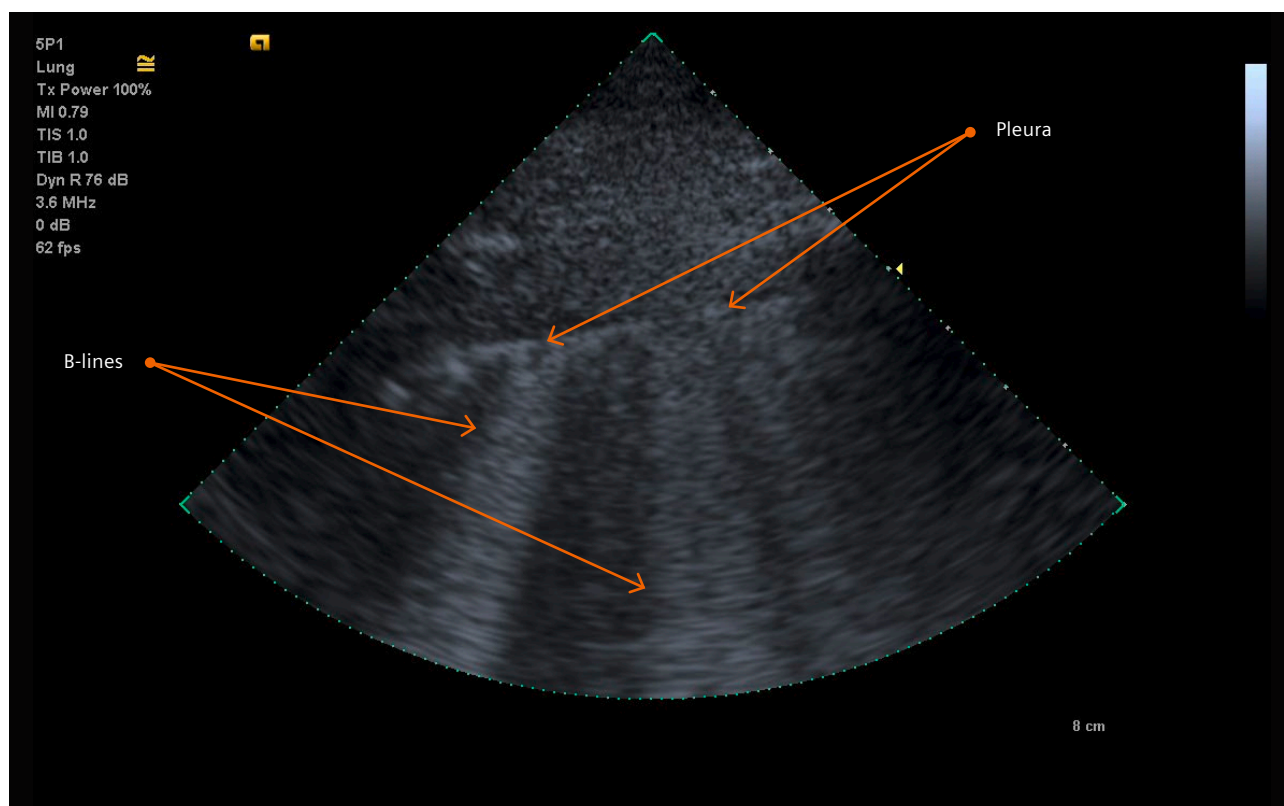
COVID-19 pneumonia. Follow-up examination in the ICU using a sector transducer. Ultrasound findings including pleural thickening and irregularity. Additionally, consolidations of the lung with B-lines are detected.
